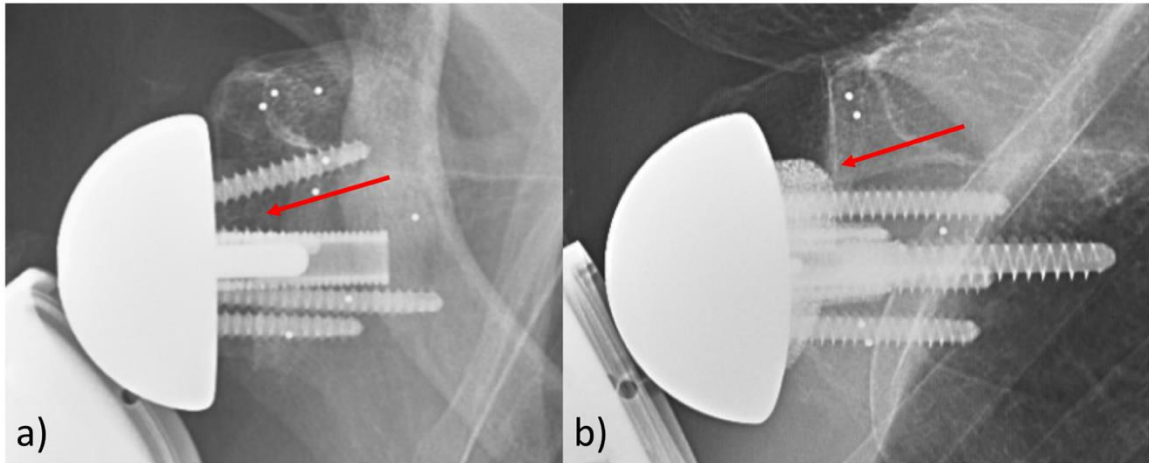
Radiographs of glenosphere augmentation (arrow) using (a) BIO-RSA and (b) the porous metal augment. Tantalum beads are also visible in the glenoid vault and coracoid as small radiopaque circles.
